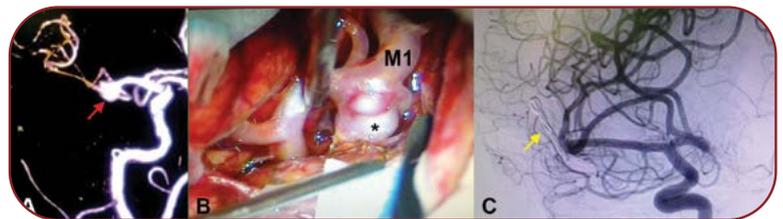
Ruptured aneurysm of right medial cerebral artery bifurcation clipped through the craniotomy shown in Figure 1. (A) Preoperative 3D reconstruction of the aneurysm (red arrow) from CT-angiogram. (B) Intraoperative image of the aneurysm (asterisk). Note that the craniotomy allows adequate exposure of the afferent/parent and the efferent arteries providing proximal and distal control as well as space for deployment of various microsurgical instruments. (C) Postoperative DSA showing complete occlusion of the aneurysm with a straight clip (yellow arrow)
